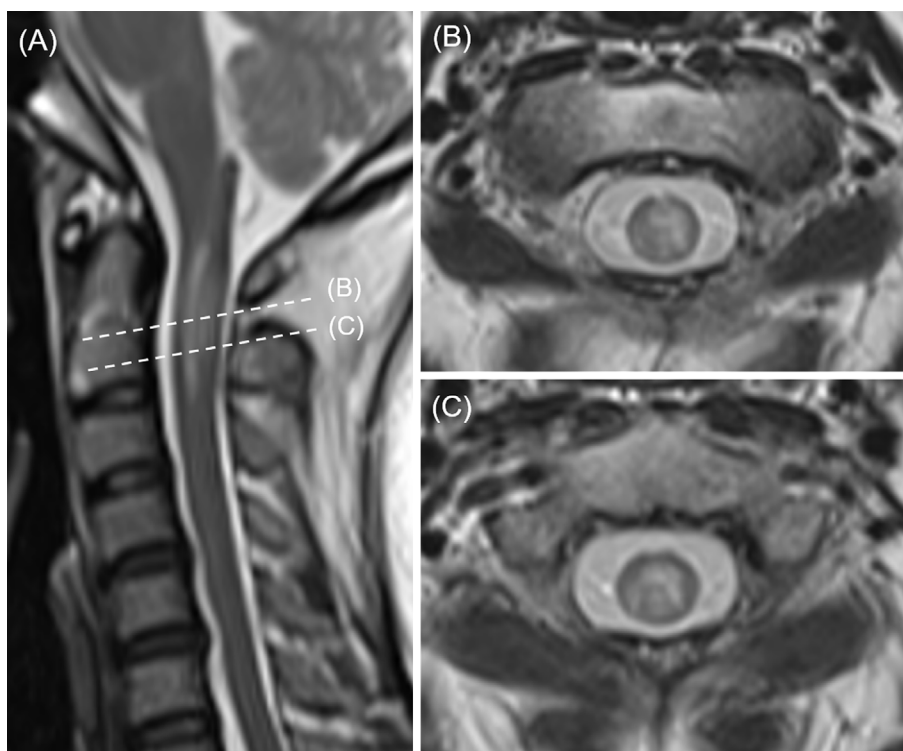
Spinal cord magnetic resonance imaging at the inflammatory episode of cervical myelitis. Sagittal (A) and axial (B, C) images on T2-weighted imaging of the cervical spinal cord showed a C2-3 lesion. The C2 lesion involved the dorsal column of the spinal cord (left side dominant).
